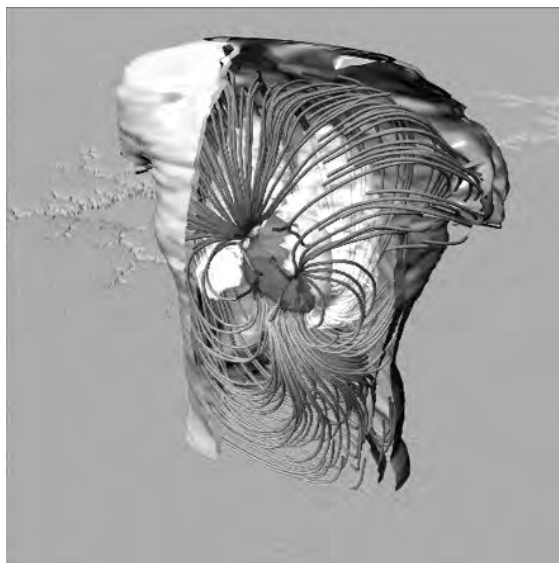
This is a graphical representation of the geometry and electrical current flow in a model of the human thorax. The model was created from MRI images taken of an actual patient. Shown are segments of the body surface, the heart, and lungs. The colored loops represent the flow of electric current through the thorax for a single instant of time, computed from voltages recorded from the surface of the heart during open chest surgery. This visualization presented particular challenges because of the complexities of the three-dimensional voltage loops
